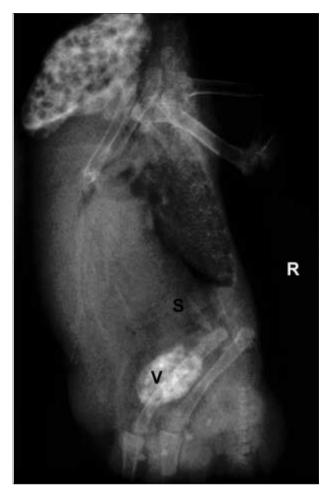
Lateral contrast radiograph of the same budgerigar. Note the soft tissue structure (S) filling the coelom. The caudal thoracic air sacs are barely identifiable. The ventriculus (V) is displaced caudally.
